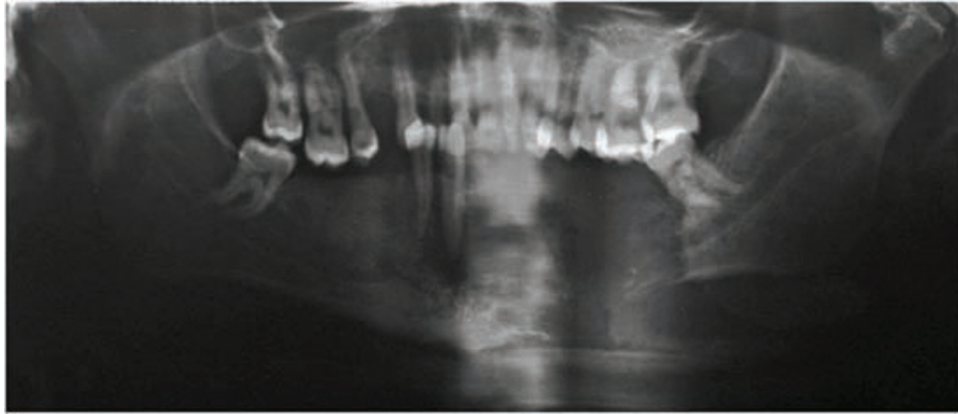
Panoramic radiography shows radiolucent area in anterior alveolar ridge and left side of the mandible, pathological fracture and involvement of the mandibular canal.
